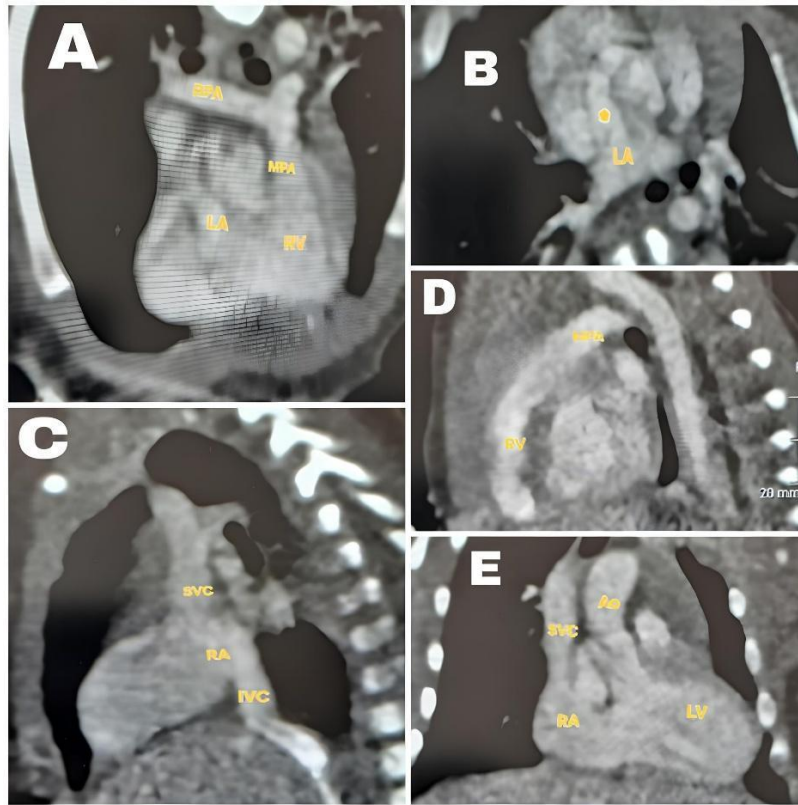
CTA images demonstrating atrioventricular and ventriculoarterial anatomy. (a) oblique axial view. LA drains into RV which gives rise to MPA. (b) oblique axial view. pulmonary veins draining into small LA that continue as a tunnel-like structure (star) to a hypoplastic RV. (c) sagittal view. SVC and IVC draining into RA. (d) sagittal view. Small anterior RV gives rise to MPA. (e) coronal view. SVC draining into RA, which empties into LV that gives rise to PA. Aorta arising from LV.
